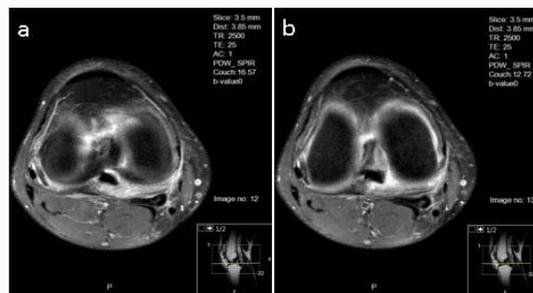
(a) Axial CT at the level of the joint line demonstrating the limited space available at the fourth compartment. (b) The following cut 3.5 mm proximally, the femoral condyls are already prominently visible, further limiting the manipulation of instruments.
